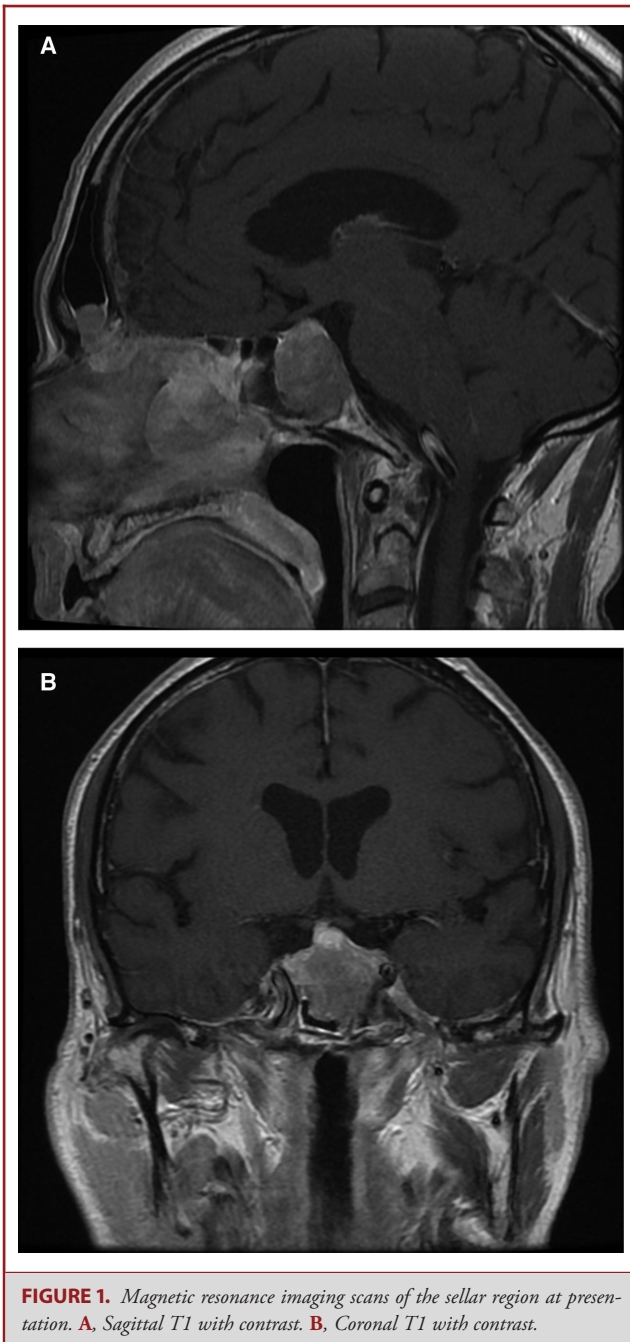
Magnetic resonance imaging scans of the sellar region at presentation. A. Sagittal T1 with contrast. B. Coronal T1 with contrast.
